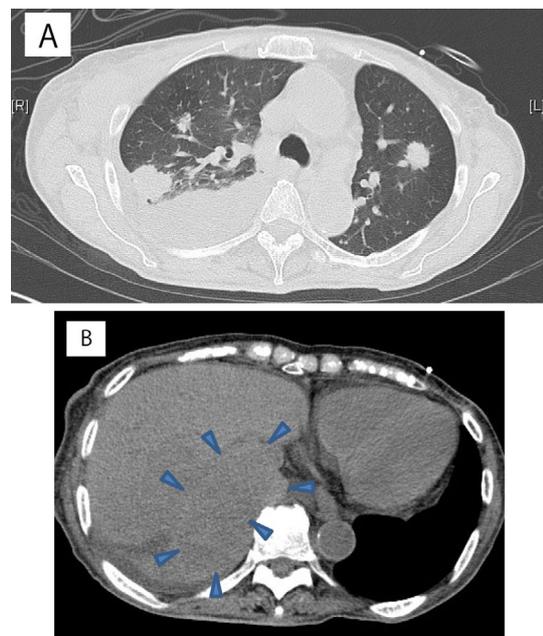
Computed tomography (CT) scans obtained in 2013. The largest mass in the right lower lobe of the lung (A) and the liver metastases (B) grew more rapidly than the other metastases, which was consistent with the emergence of a tumor with higher-grade morphology.
